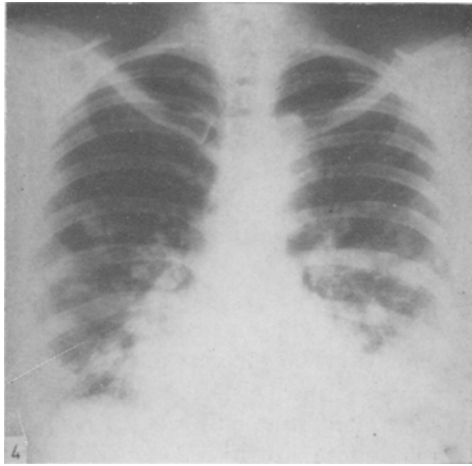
Case 4*: Preoperative chest X-ray of a 45-year-old woman: multiple pulmonary metastases on both sides
